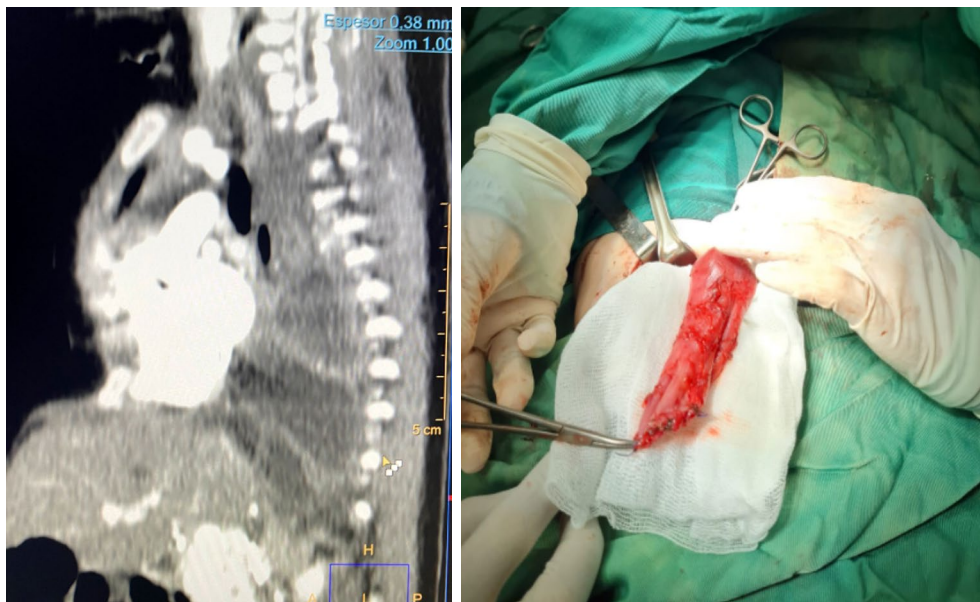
Computed tomography demonstrates the second cyst 47×43×21 mm in size and 55 mL in volume, located extrapleurally near the right paravertebral area. A layer of muscle is visible in the intraoperative image of the second esophageal duplication cyst.
